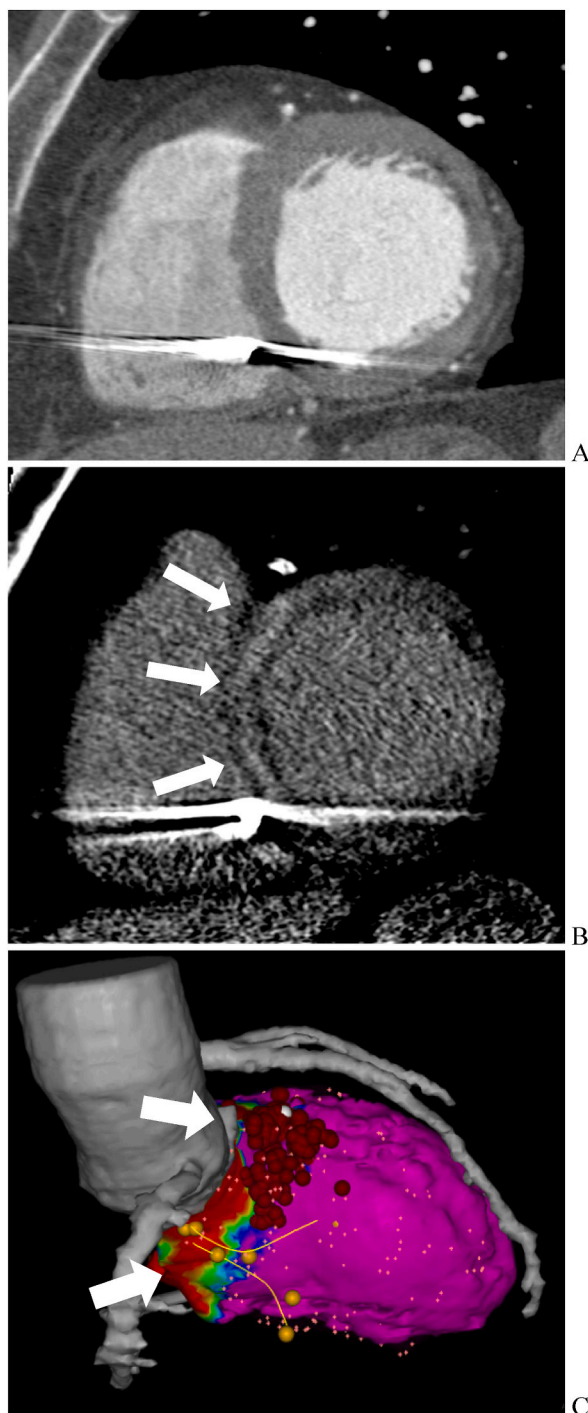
Multiparametric CT including an angiographic scan (A) and a low voltage late contrast enhancement scan (B) in a patients with ICD suffering from recurrent ventricular tachycardia. Myocardial wall thickness resulted preserved in CTA (A) while LCE-CT showed a mesocardial scar (white arrows in B) involving the basal interventricular septum. The streaks artifact from ICD minimally interfered with the assessment of scar in the posterior septum. Electroanatomic mapping obtained with an endocardial approach (C) confirmed low voltages in the basal septum (red area with white arrows in C) corresponding to scar identified by LCE-CT, hence ablation was successfully performed on the border zone of that area (red dots in C). (For interpretation of the references to color in this figure legend, the reader is referred to the Web version of this article.)
